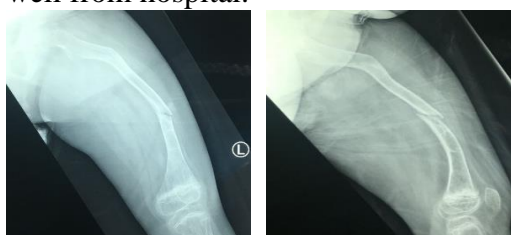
Pre operative radiograph showed antecurvature 30 degree with fracture.
